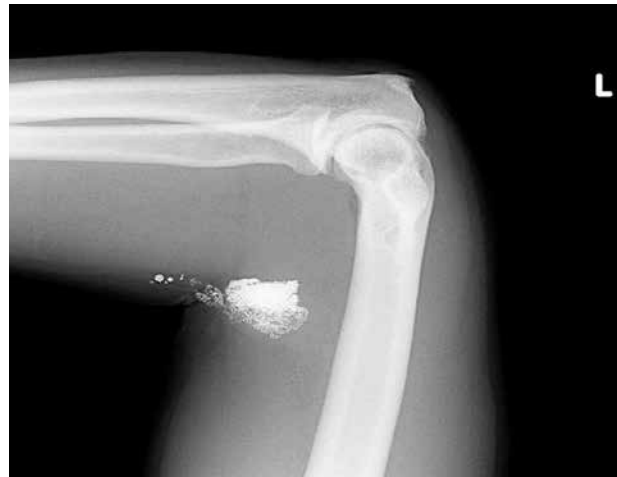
X-ray of left arm showing subcutaneous radio-opaque deposits in antecubital fossa
